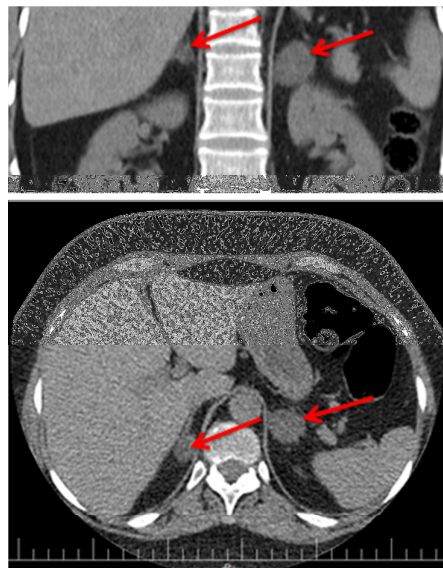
The bilateral adrenal nodules in Abdominal CT Scan
